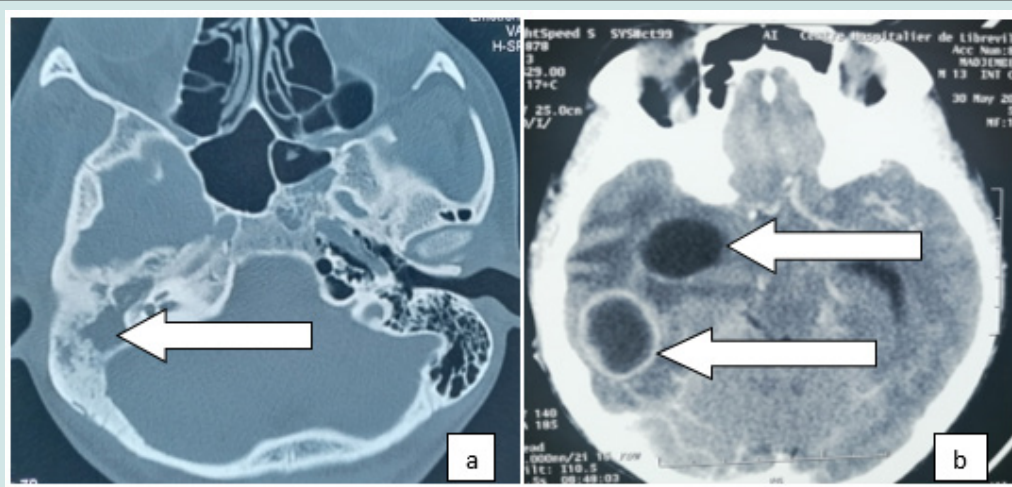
a: CT of the petrous bones in axial section showing mastoid cell filling (arrow)
